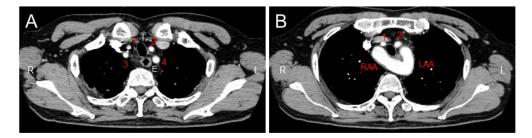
Contrast-enhanced computed tomography image, horizontal planes.
